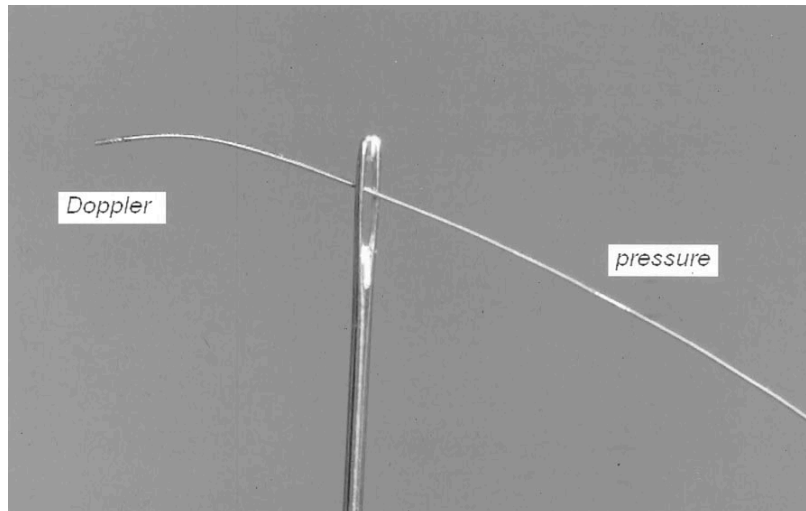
0.014" Dual-sensor guide wire, Combwire® (Volcano Therapeutics™, USA). On this version of the wire (model 9515), the pressure sensor is offset by 30mm from the Doppler sensor which is situated at the tip of the wire. Another version is available (model 9500) where both sensors are situated at the tip, although this can be more difficult to manipulate in tortuous vessels or across tight lesions.
